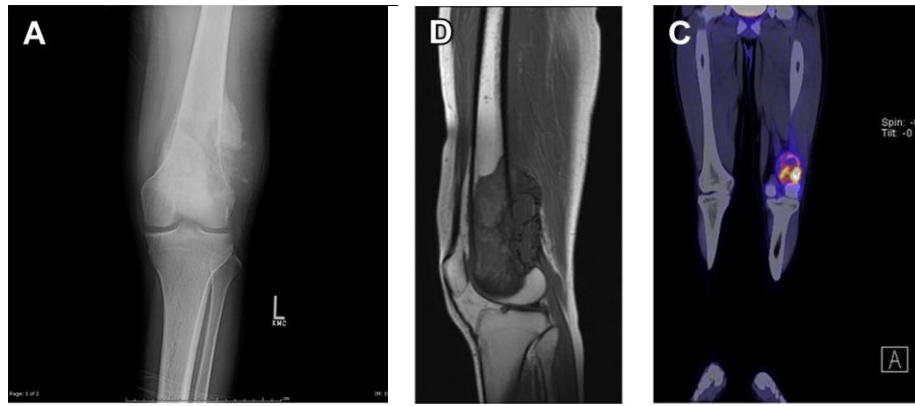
Comparison between imaging techniques from a young man with left knee pain for 1 month. (A) radiograph of distal femur shows aggressive tumor. (B) MRI of the distal femur. (C) PET/CT scan of left femur. Adapted from [2].
